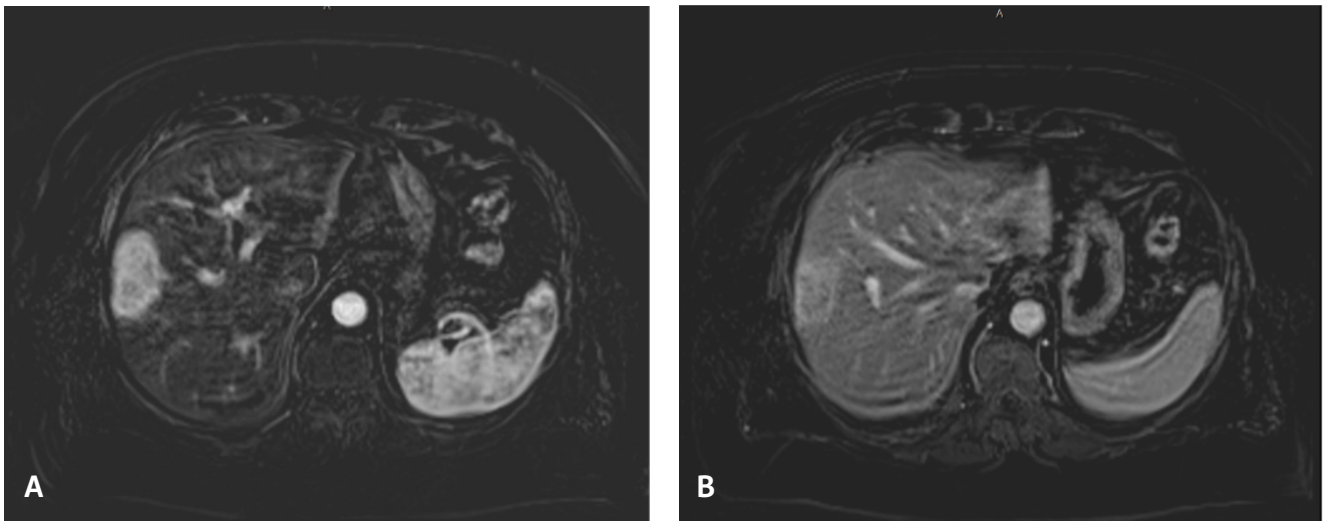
MRI of the abdomen with contrast. MRI images showed a right hepatic lesion in segments 5 and 8 with (A) enhancement on the arterial phase and (B) washout on the venous phase.
